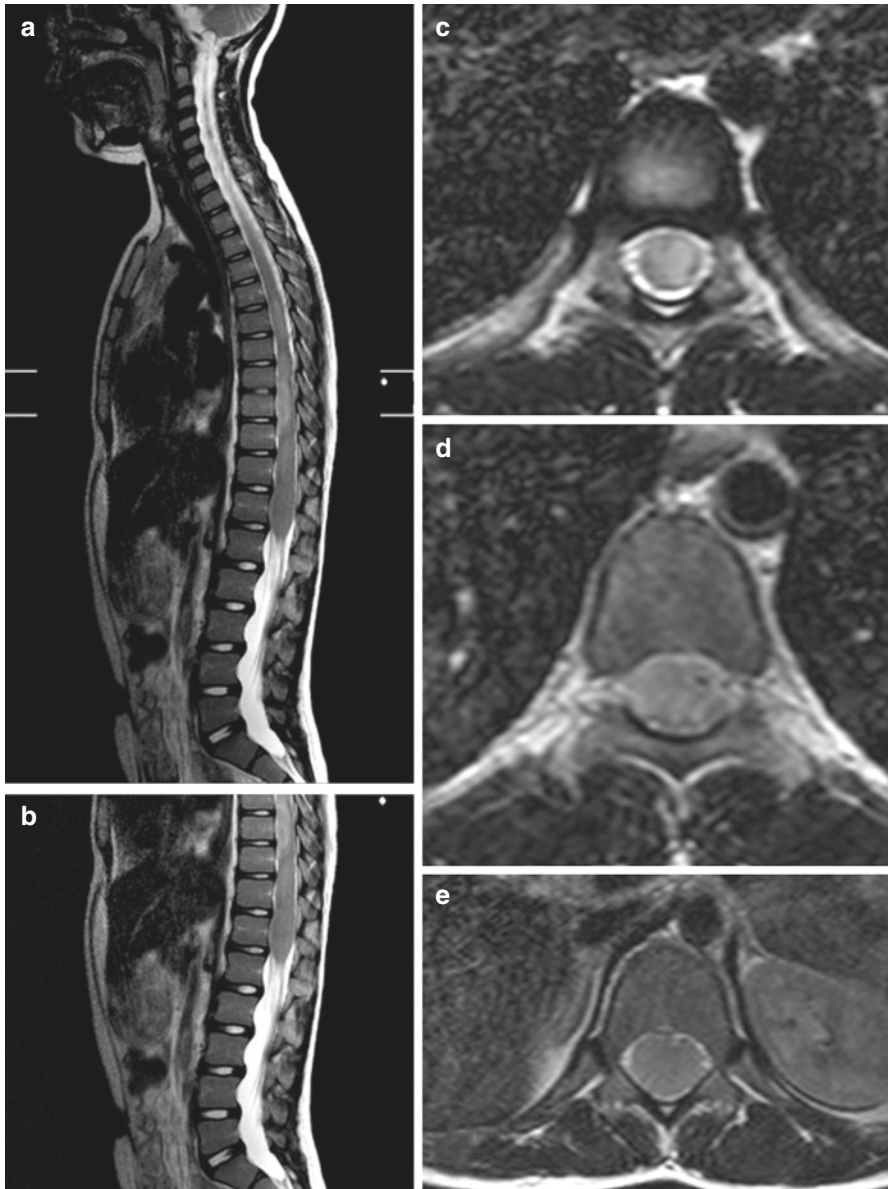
(a) Sagittal T2-weighted MRI of spinal cord that is diffusely infiltrated by astrocytoma. (b) Diffuse involvement and enlargement of the spinal cord by highly aggressive and infiltrative intramedullary spinal cord astrocytoma. Axial T2-weighted MRIs of the spinal cord at the mid-thoracic (c, d) and lower thoracic (e) level that are revealing the totally infiltrated by the tumor
